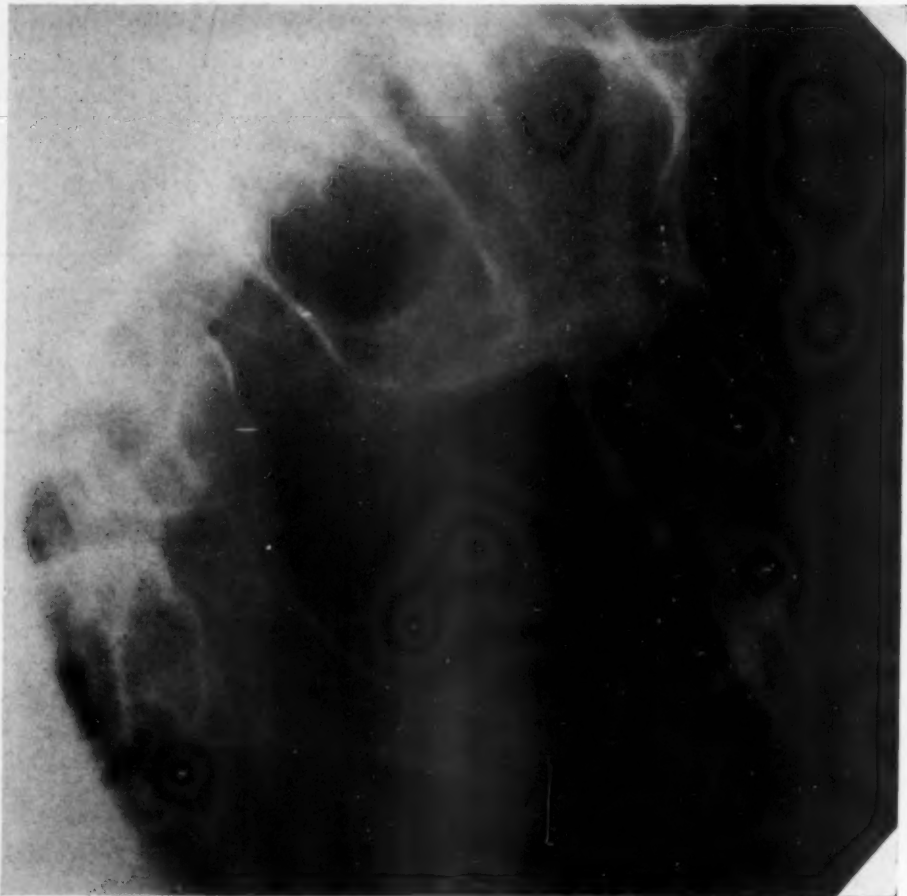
X-ray of mandible showing anodontia.
